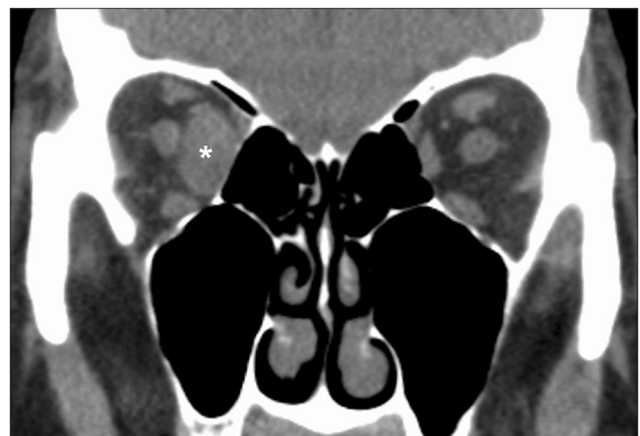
A coronal view on computed tomography of the face, demonstrating enlargement of the right medial rectus muscle (asterisk) secondary to invasion of cutaneous squamous cell carcinoma of the eyelid
